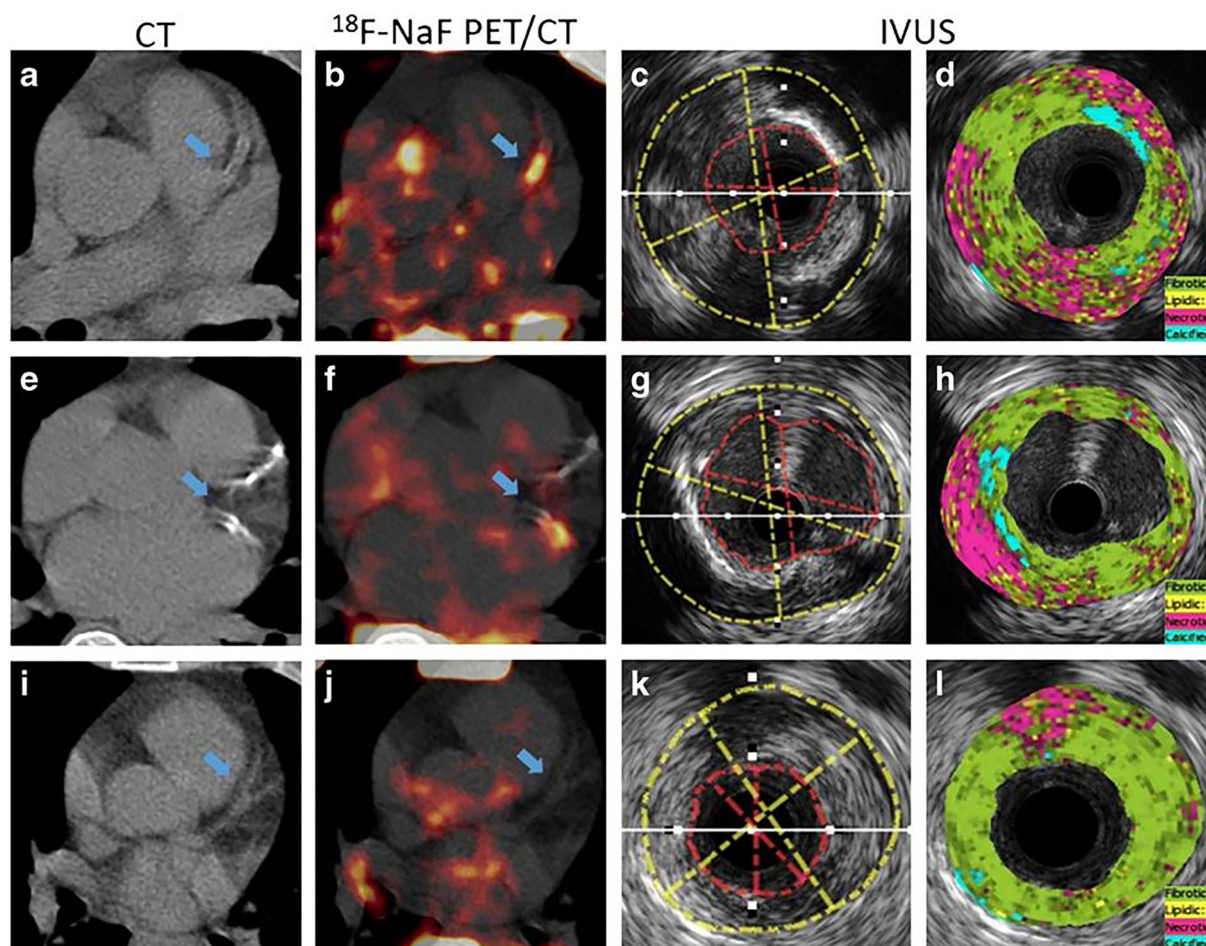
CT, fused NaF-PET/CT, and IVUS images from three patients with unstable angina. While lesions with spotty calcification (a–d) and a large necrotic core (e–h) were NaF avid, the fibrotic lesion (i–l) did not
